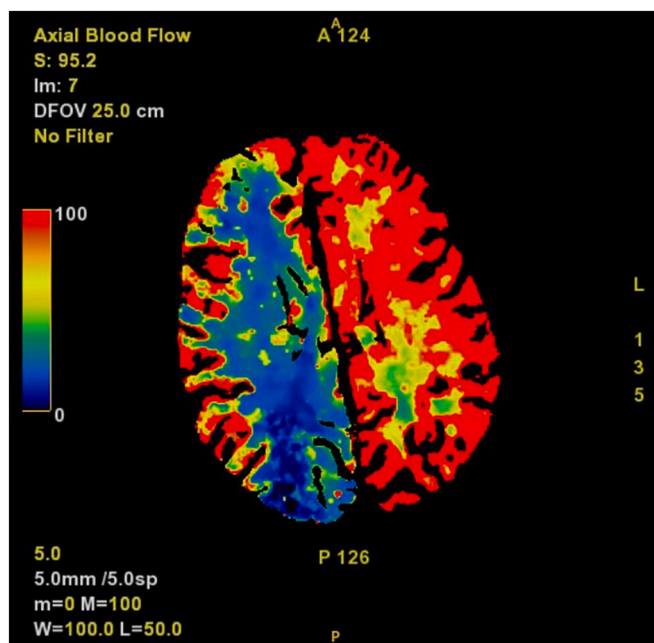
CT perfusion study demonstrating hypoperfusion of the right cerebral hemisphere.
